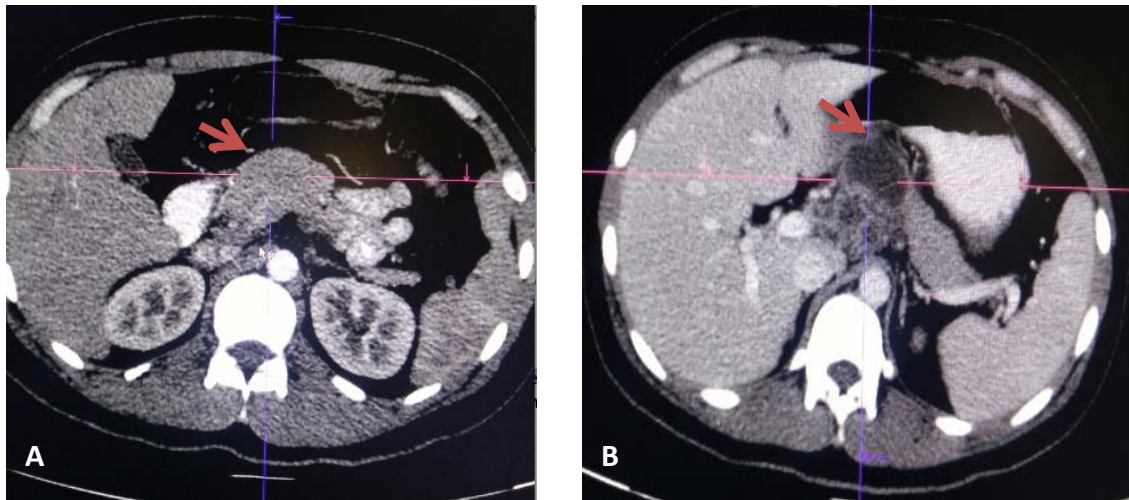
Contrast enhanced abdominal computed tomography scan showing a fairly-defined, predominantly cystic mass in the pancreatic head and body region (red arrow) in arterial phase (A) and venous phase (B), with minimal perilesional fat stranding and multiple lymphadenopathies.
